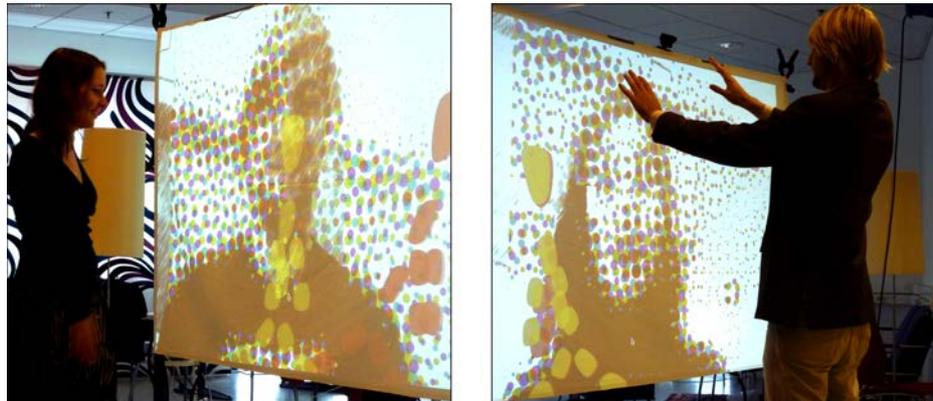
The winning concept, Social X-ray (designed by Mieke Kleppe, Bo Merkus, Laleh Omalaki and Steffen Streatz) is an interactive, two-sided wall. It shows three things; a vague human shape representing the user, mimicking his or her movements, another similar shape, mimicking the movements of the person on the other side of the wall, and a background image showing a distorted image of the person on the other side. The image gets sharper if the user moves much or goes very close to the wall. The general idea is to persuade people to interact with the strangers around them, in a public place
